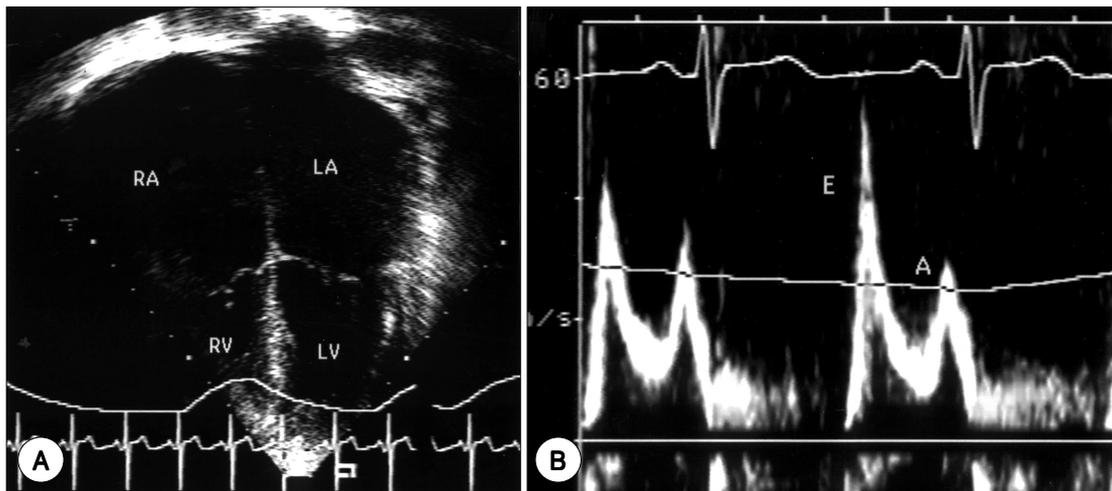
Echocardiographic features of restrictive cardiomyopathy. A : Apical 4 chamber view demonstrates severe left atrial enlargement. B : Pulsed Doppler mitral inflow pattern ; rapid E wave deceleration, high E/A velocity ratio.
